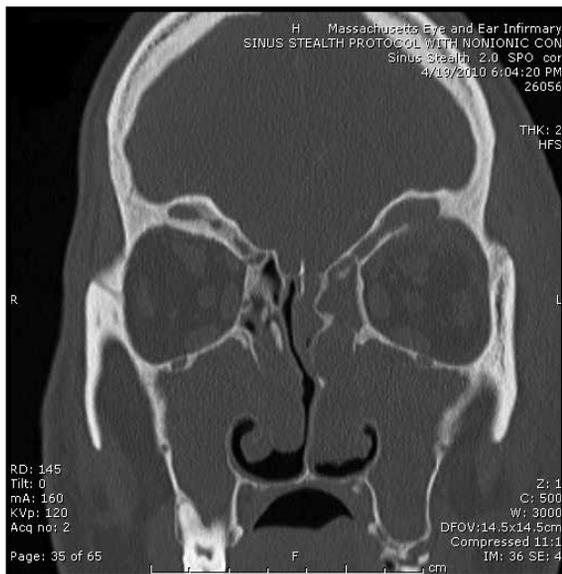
Left orbital roof erosion from left frontal sinus mucocele and extensive pan-sinusitis. CT Coronal view, bone window.
